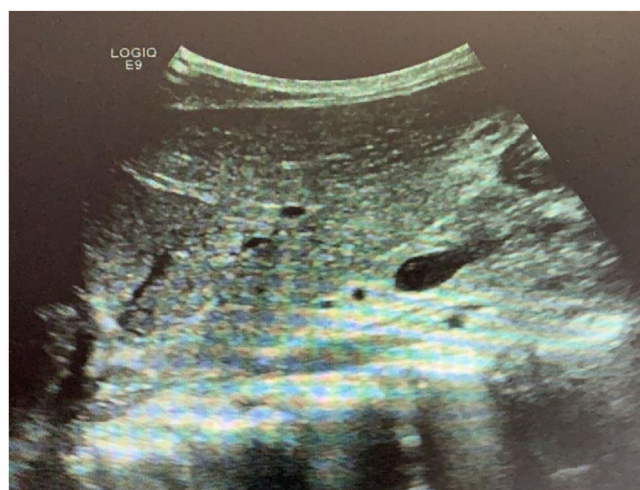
Control ultrasound image before hospital release.
